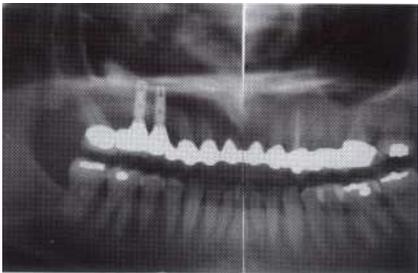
Panorex radiograph taken 2 years after grafting (15 months after placement of implants).
